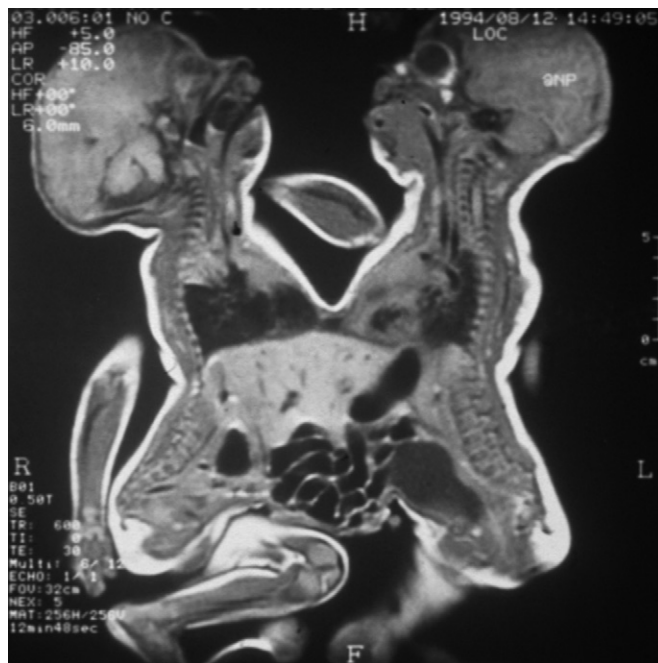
Computed tomography scan of thoracopagus conjoined twins.
